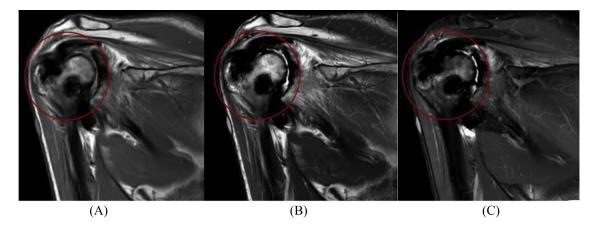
MRI right shoulder Coronal section (A) T1, (B) T2, (C) PDFS shows: hypointensity on T1/T2/PDFS in the tendon of supraspinatus, subscapularis and long head of biceps (red circles).
